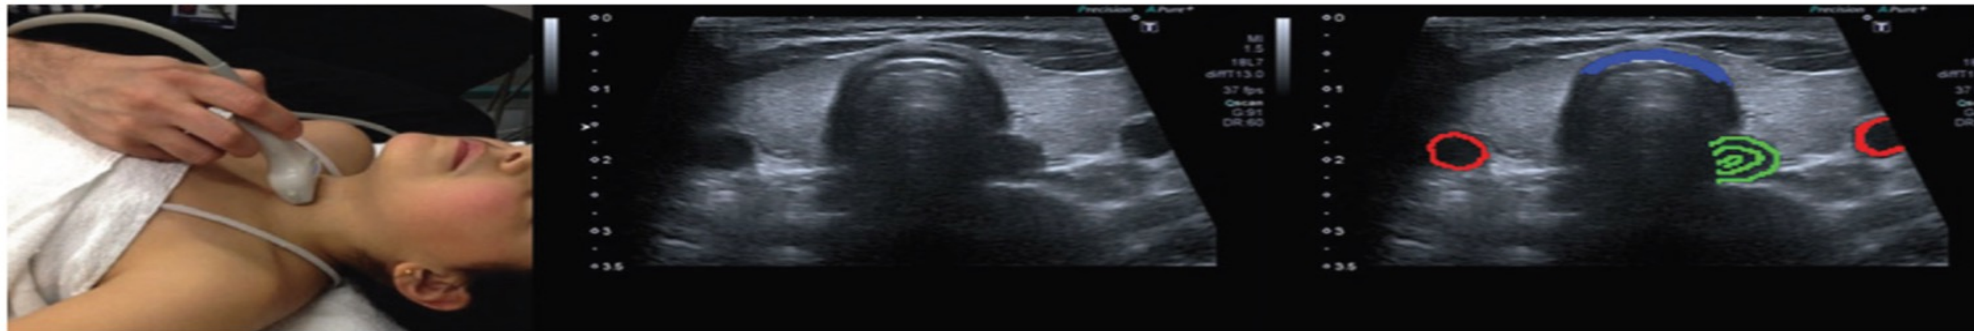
Ultrasound of transverse view of trachea
